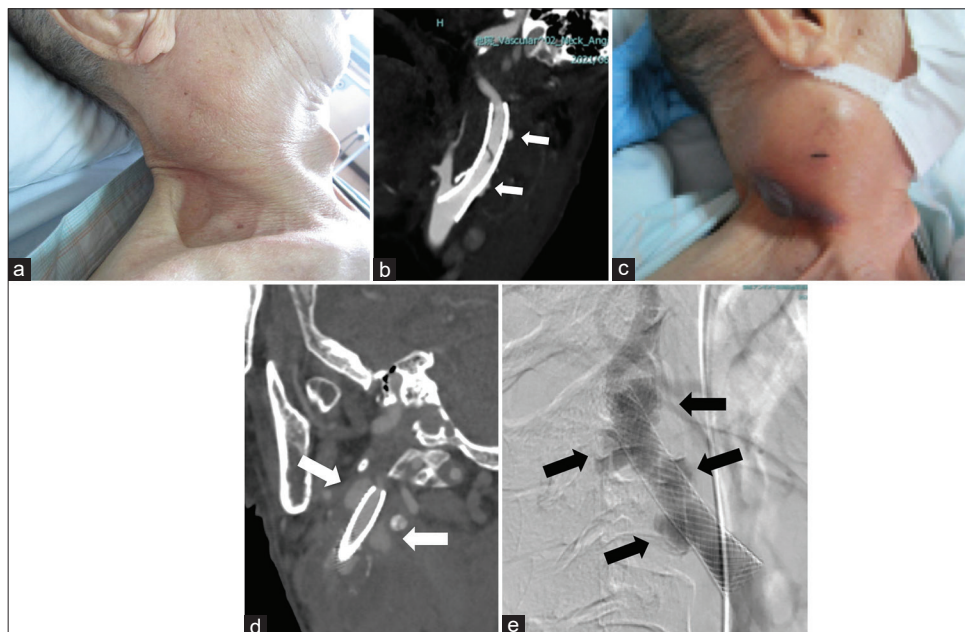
Clinical images before surgery. (a) Picture taken on the day the patient was transferred to our hospital showing swelling of the right side of the neck. (b) CTA taken the day the patient was transferred to our hospital showing the stent placed in the right ICA-CCA and contrast material outside the stent (arrow). (c) Picture taken 2 weeks after admission showing growth of the mass. (d) CTA taken 2 weeks after admission showing an increase in the size of the region that contrast material was flowing into outside the stent (arrow). (e) DSA showing contrast material flowing outside the stent (arrow). CTA: Computed tomography angiography, ICA: Internal carotid artery, CCA: Common carotid artery, DSA: Digital subtraction angiography.
